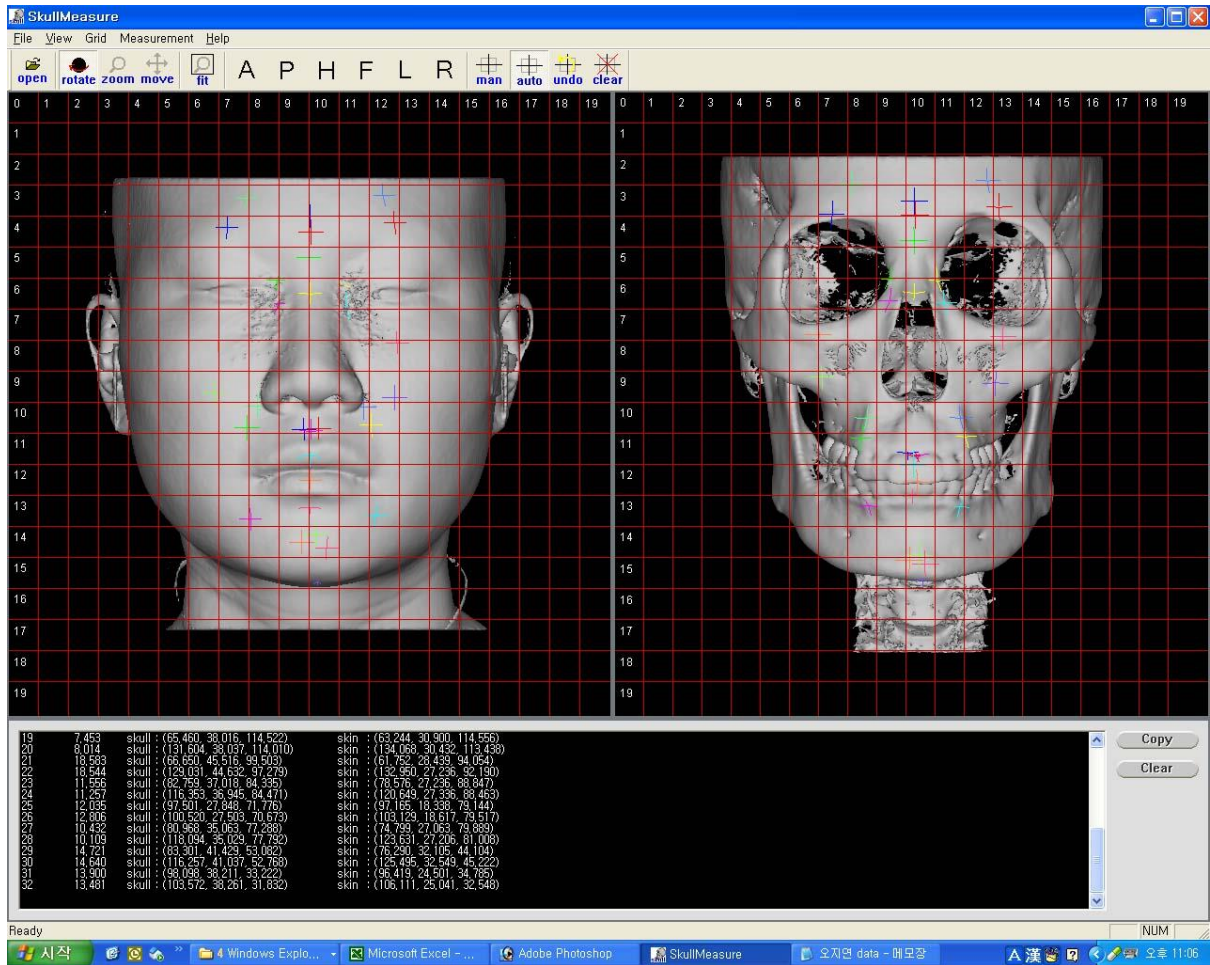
A window of the Skull Measure program used to measure soft tissue depths on cone-beam CT images. Both soft and hard tissue images are rotated freely so the landmarks are identified accurately according to their definitions. Once the position is established on the soft tissue image, enabling the corresponding point is designated automatically on the hard tissue image enabling the investigator to confirm the correct position of the landmark.
